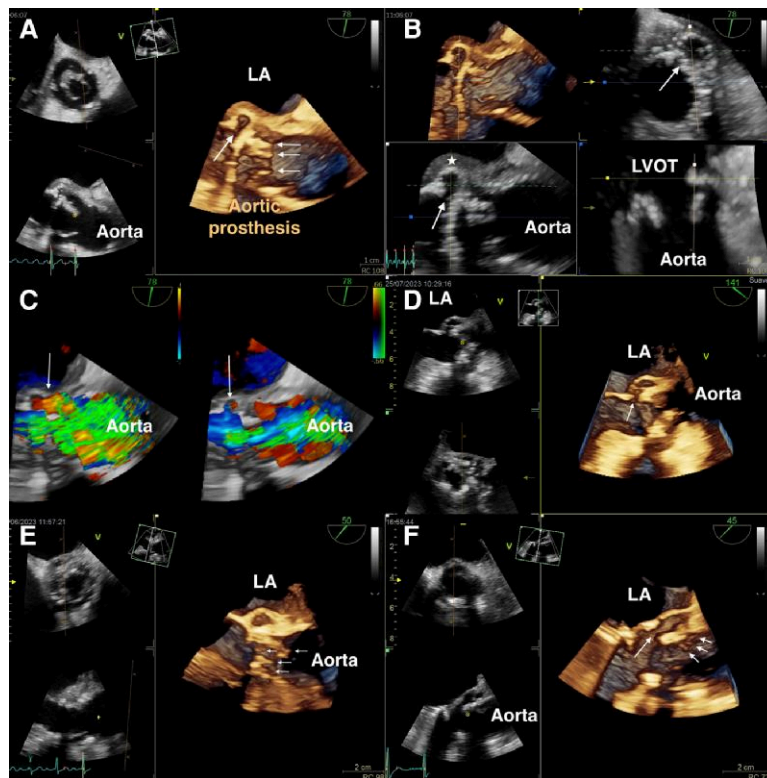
Pseudoaneurysm. (A) TOE at mid-oesophageal level acquired at 78°, volume rendering. Biological aortic prosthesis with evidence of pseudoaneurysm of the mitroaortic fibrosa (white arrow) communicating with the left ventricular outflow tract. Additionally, multiple vegetations are visible inside it (thin white arrows). (B) MPR of the previous case, showing the pseudoaneurysm in short and long axes, and thickening of the containing wall, corresponding to an abscess (white star). (C) Volume rendering with colour Doppler of the same patient. Non-simultaneous biplanar images show flow passage from the aorta to the cavity (white arrow, left image) and from the cavity to the left ventricular outflow tract (white arrow, right image). (D) TOE at mid-oesophageal level acquired at 141°, volume rendering. Biological aortic prosthesis focus, showing pseudoaneurysm of the mitroaortic fibrosa (white arrow) connected to the left ventricular outflow tract. It is important to note the thickening of the leaflets. (E) TOE at mid-oesophageal level acquired at 50°, volume rendering. Biological aortic prosthesis focus, showing pseudoaneurysm of the mitroaortic fibrosa with thickened lining, and additionally, multiple vegetations are appreciated in the prosthetic arterial aspect. (F) TOE at mid-oesophageal level acquired at 45°, volume rendering. Biological aortic prosthesis focus, showing pseudoaneurysm of the mitroaortic fibrosa communicating with the left ventricular outflow tract (long white arrow), and small vegetations are also visible inside it (small white arrows). Note the presence of a mechanical mitral prosthesis. LA, left atrium; LVOT, left ventricular outflow tract.
